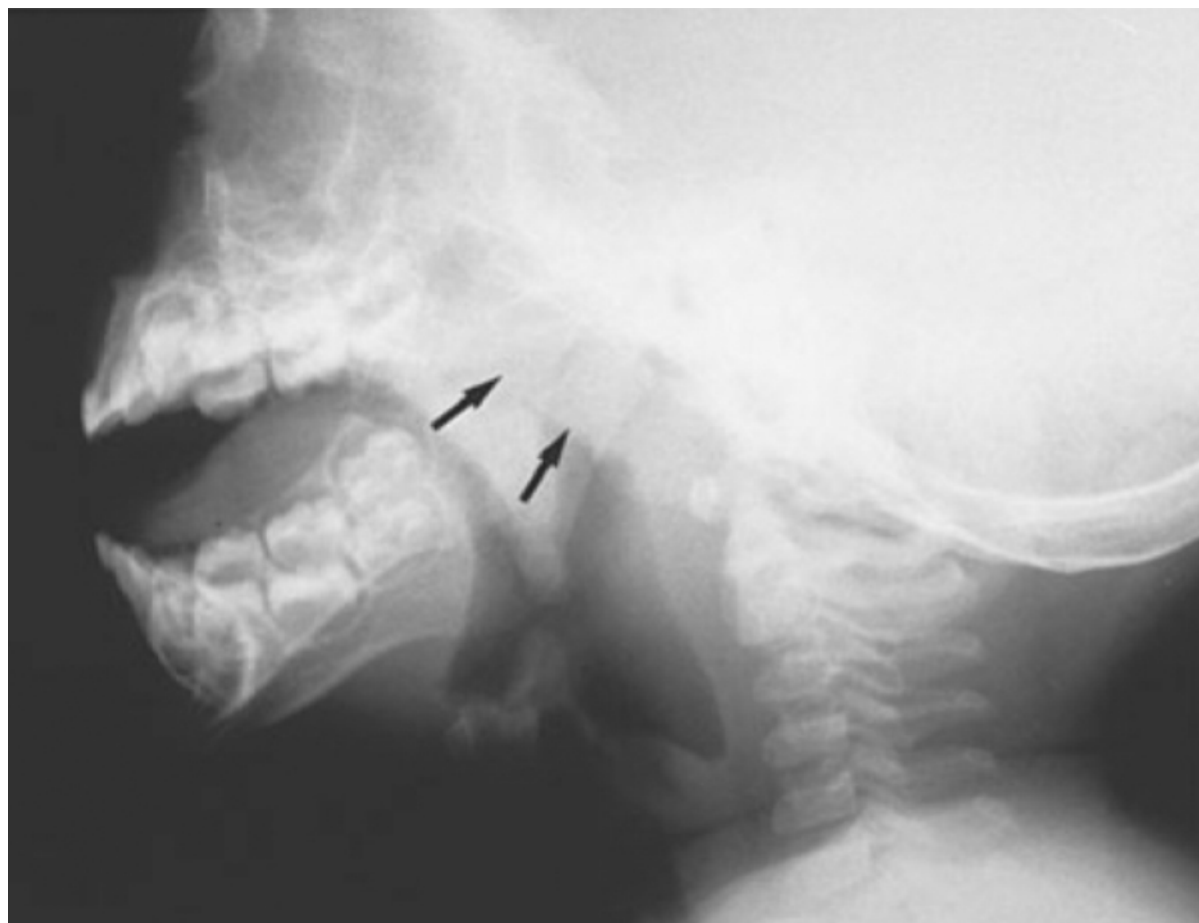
Lateral soft tissue radiograph of the nasopharynx demonstrating an enlarged adenoid pad (*arrows*).
